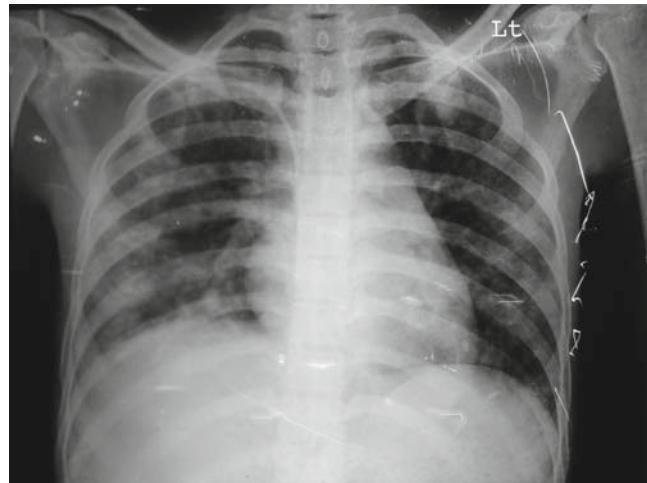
On day 1, chest X-ray confirmed the placement of the tip of the central venous catheter (CVC) in the right atrium, with no evidence of pneumothorax or cardiac tamponade. *Lt*, Left
